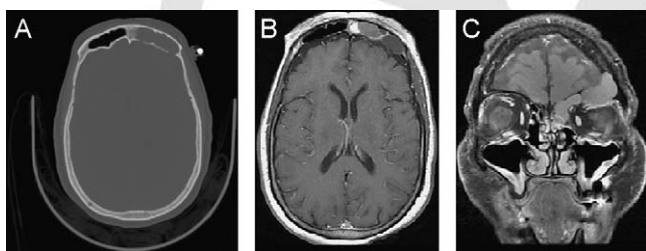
Patient #2: Pre-operative axial CT scan (A) and contrast-enhanced axial (B) and coronal (C) T₁-weighted MRI demonstrating a left frontal sinus mucocoele with dehiscence of the posterior table of the frontal sinus, intracranial extension, and orbital extension with mass effect on the left orbit.
